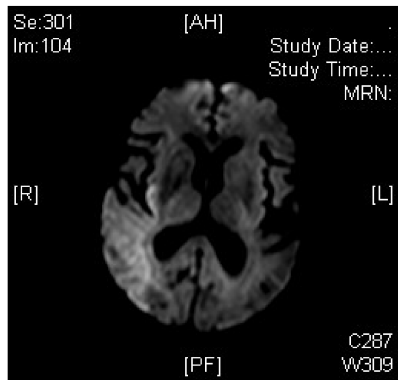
MRI Brain Revealing an Acute Evolving RMCA Infarct which is Bright on DWI Sequence (Fig 1) and Shows Signal Loss on ADC Sequence (Fig 2)
